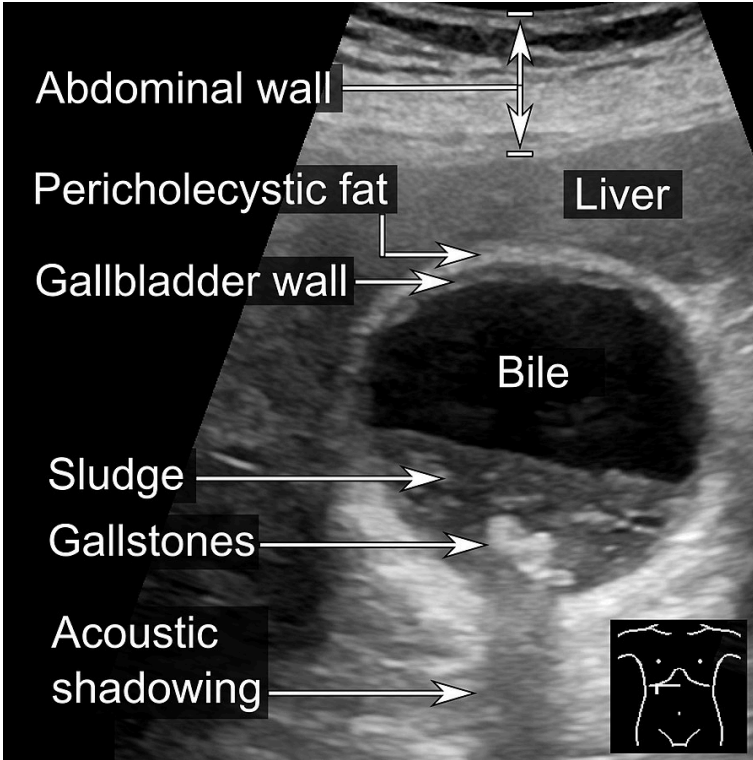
The stones in gallbladders are very bright, and they cast an acoustic shadow posterior to the stones. [Ultrasound of sludge and gallstones, annotated](#) by Kitmondo Marketplace licensed under [CC0 2.0](#)
